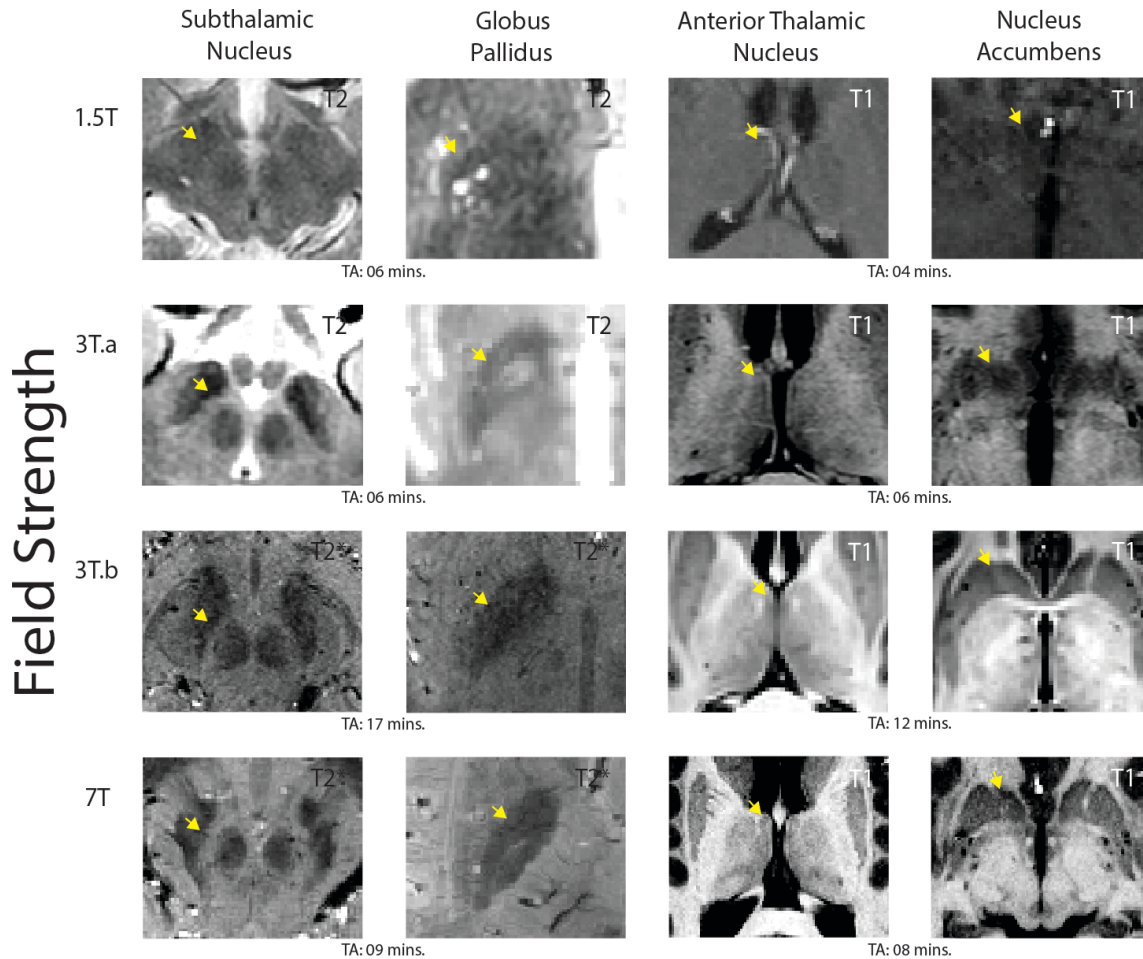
Visualizing DBS targets with different MRI field strengths. 1.5T images were obtained from a 52-year-old male Parkinson's disease patient at the Maastricht University Medical Centre (MUMC). Clinical 3T and 7T images were obtained from a 57-year-old male Parkinson's disease patient at the Maastricht University Medical Centre (MUMC). The optimized 3T images were obtained from a healthy male age-matched subject at the Spinoza Centre for Neuroimaging, Amsterdam. All images are shown in the axial plane, in their native space with no post-processing to replicate visualization as performed on neurosurgical planning software. The T1 contrasts show the anterior thalamic nucleus and nucleus accumbens at all field strengths. The subthalamic nucleus and globus pallidus (GP) are shown with a T2 contrast at 1.5T and clinical 3T scan. Note that in the 7T contrast, the medial medullary lamina is visible, and allows to distinguish between the internal and external segment of the GP. For optimized 3T and 7T the STN and GP are shown with a T2\* contrast. The acquisition times (TA) for each scan are included to highlight the fact that optimized 3T can provide high-quality images similar to those at 7T, but take nearly twice as long to obtain. While the STN and GP are visible in both 3T images, the contrast and sharpness of borders increases at 7T.
